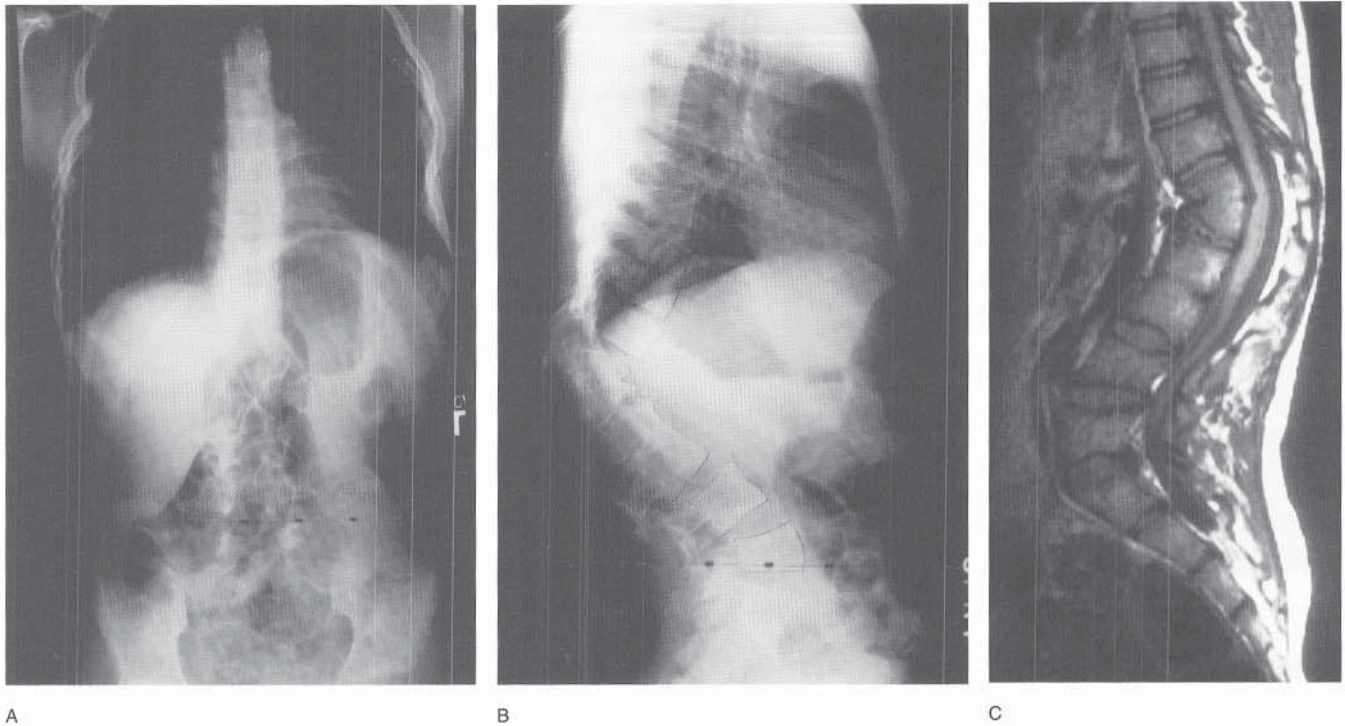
This neurologically normal 14-year-old boy had back pain and progressive worsening of his back appearance. Radiographs demonstrated failure of segmentation at T12–L1 and L2–3 with a resultant 82-degree localized kyphosis (A, B). MRI showed a normal spinal cord (C).
